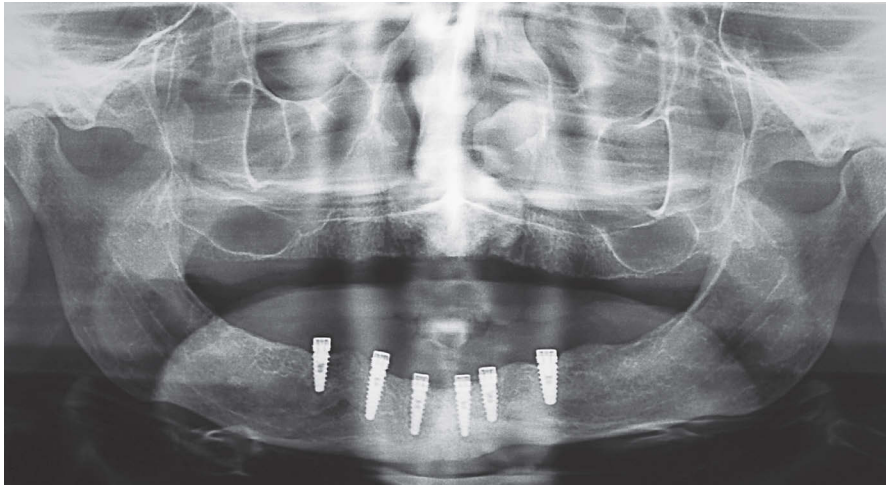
Panoramic radiograph nine months after implant placement.
